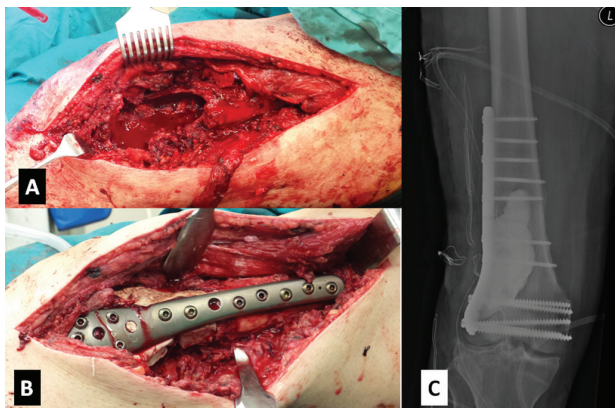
A/B: Intraoperative images showing tumor curettage (A) and fixation with PMMA-locking plate (B). An immediate postoperative anteroposterior x-ray is also depicted (C).
